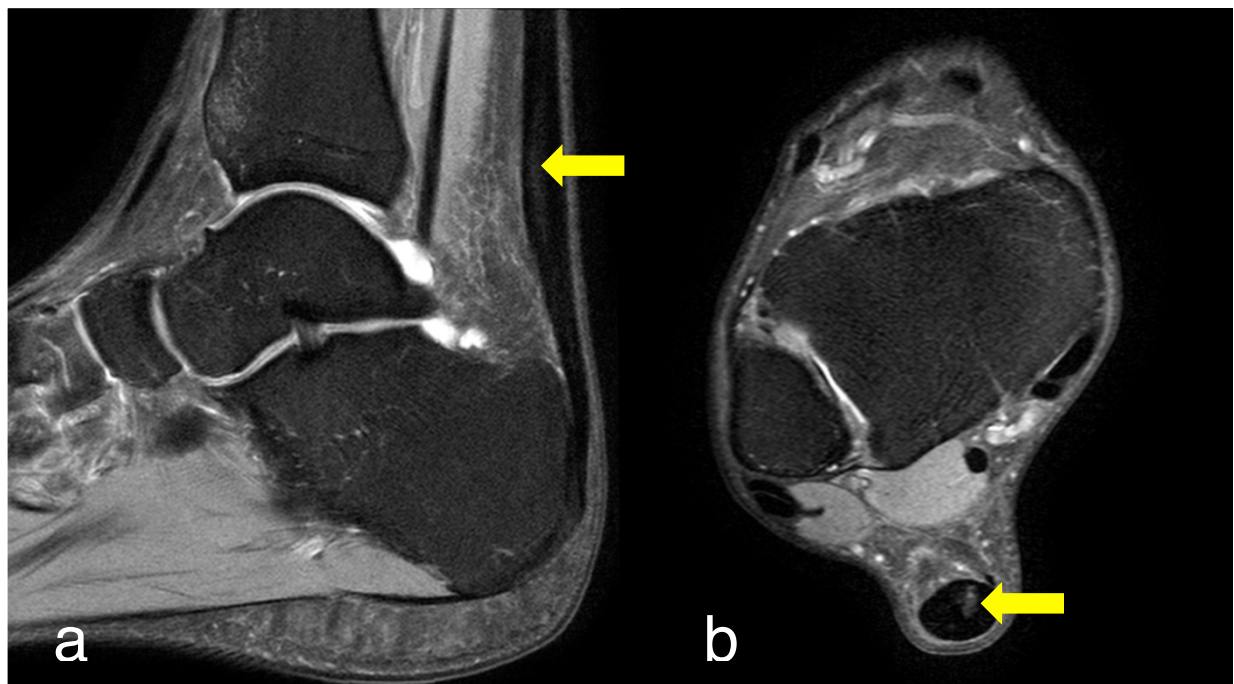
Magnetic resonance imaging of an abnormal Achilles tendon. (a) Longitudinal and (b) transverse image revealing increased signal intensity (yellow arrow) within the midsubstance of the tendon
